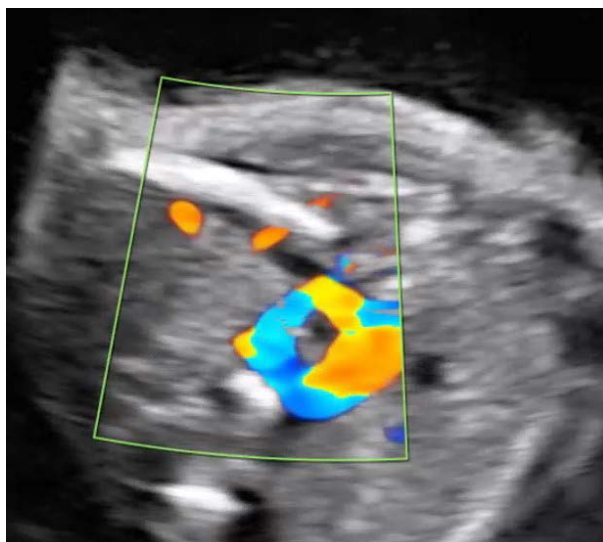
Color Doppler of at the same level showing O-shaped vessel arrangement consistent with double aortic arch
